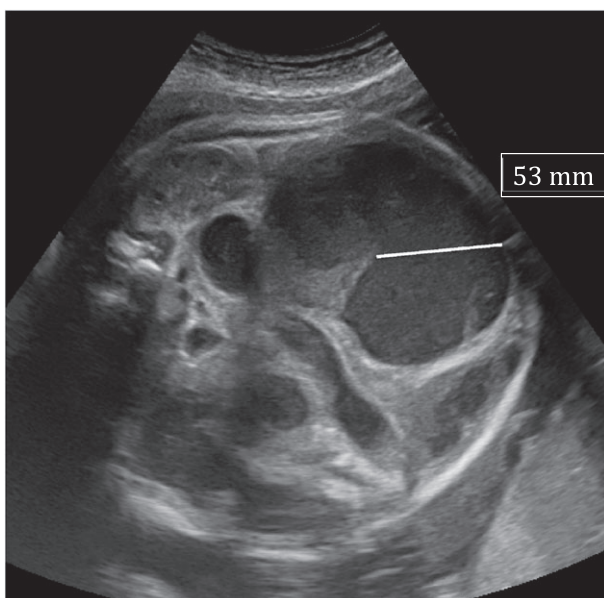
Case #9, 22 weeks of gestation. Prenatal midgut volvulus: Ultrasound features: whirlpool sign associated with massive intestinal dilatation at 22 weeks (axial ultrasound image)
